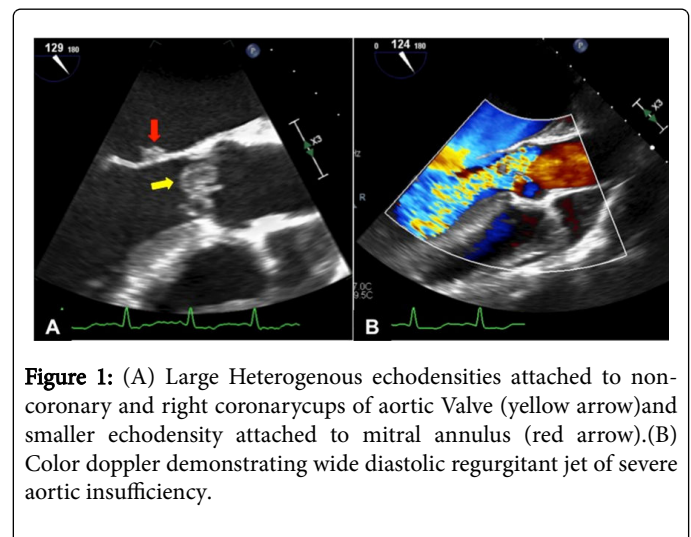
(A) Large Heterogenous echodensities attached to non-coronary and right coronary cups of aortic Valve (yellow arrow) and smaller echodensity attached to mitral annulus (red arrow). (B) Color doppler demonstrating wide diastolic regurgitant jet of severe aortic insufficiency.
